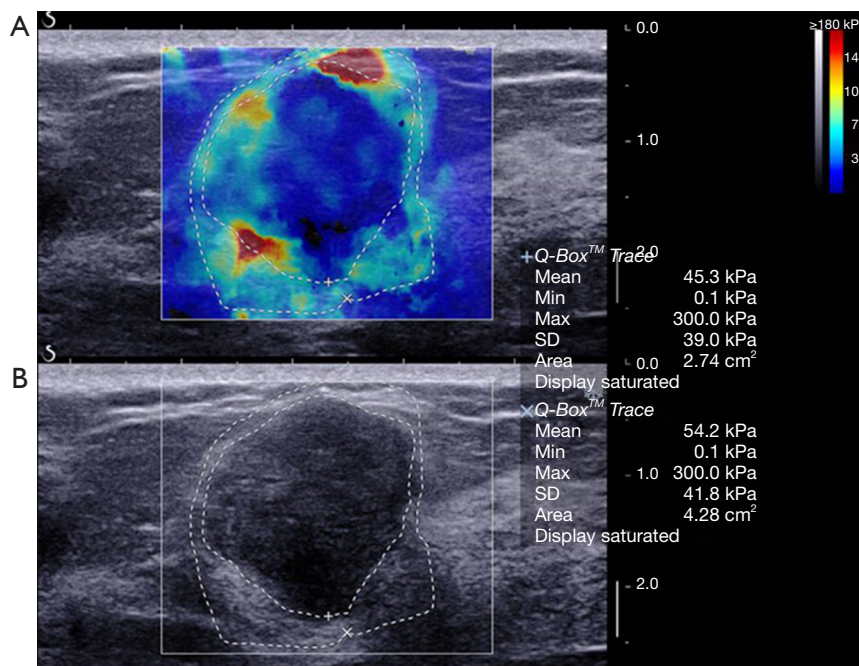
A 61-year-old woman diagnosed with a 22 mm, borderline phyllodes tumor. The lesion was assessed as BI-RADS category 4a on US image (B), the SWE image (A) shows Emax of 300.0 kPa. The lesion would be upgraded to BI-RADS category 4b by using the aggressive and conservative approaches with combined assessment of US and SWE. SD, standard deviation; BI-RADS, Breast Imaging-Reporting and Data System; US, ultrasound; SWE, shear-wave elastography; Emax, maximum elasticity.
